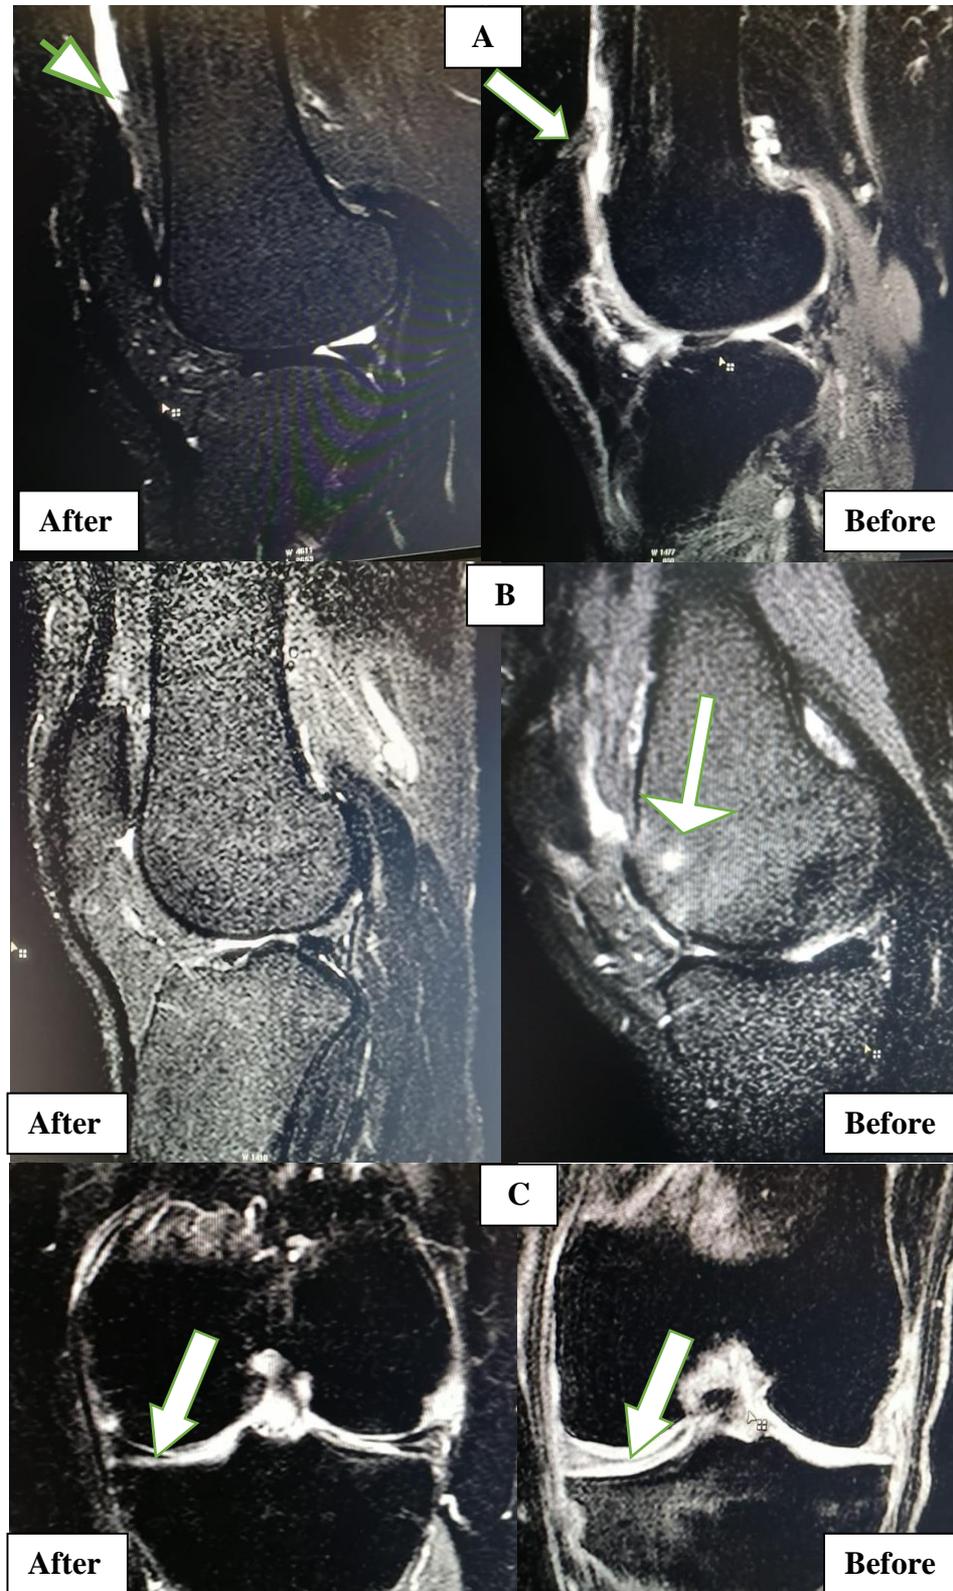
MRI analysis of knee joint before the first IA injection of PRP and 2 weeks after the second IA PRP injection, MRI signals showed significant improvements in synovitis (A) and bone marrow lesions (B) with no improvement in cartilage loss(C) compared with the pre injection knee joint
